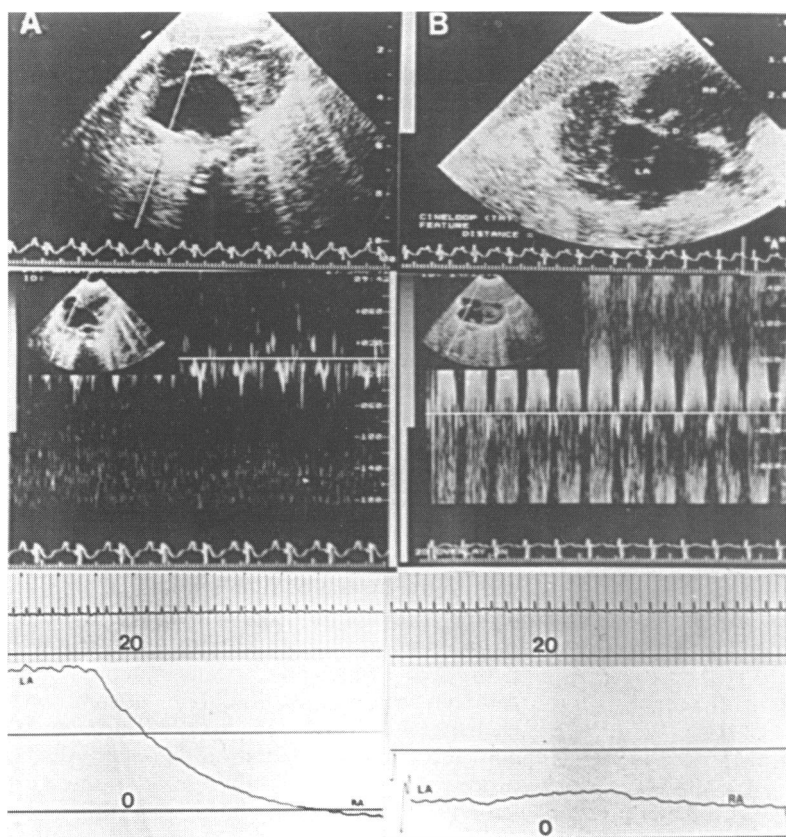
Cross sectional echocardiogram, pulse wave Doppler, and pull-back pressure tracing from right to left atrium before (A) and after (B) initial balloon dilatation in an infant eight months old with univentricular heart, pulmonary stenosis, and severe stenosis of the left atrioventricular valve (RA, right atrium; LA, left atrium; D, atrial septal defect).
